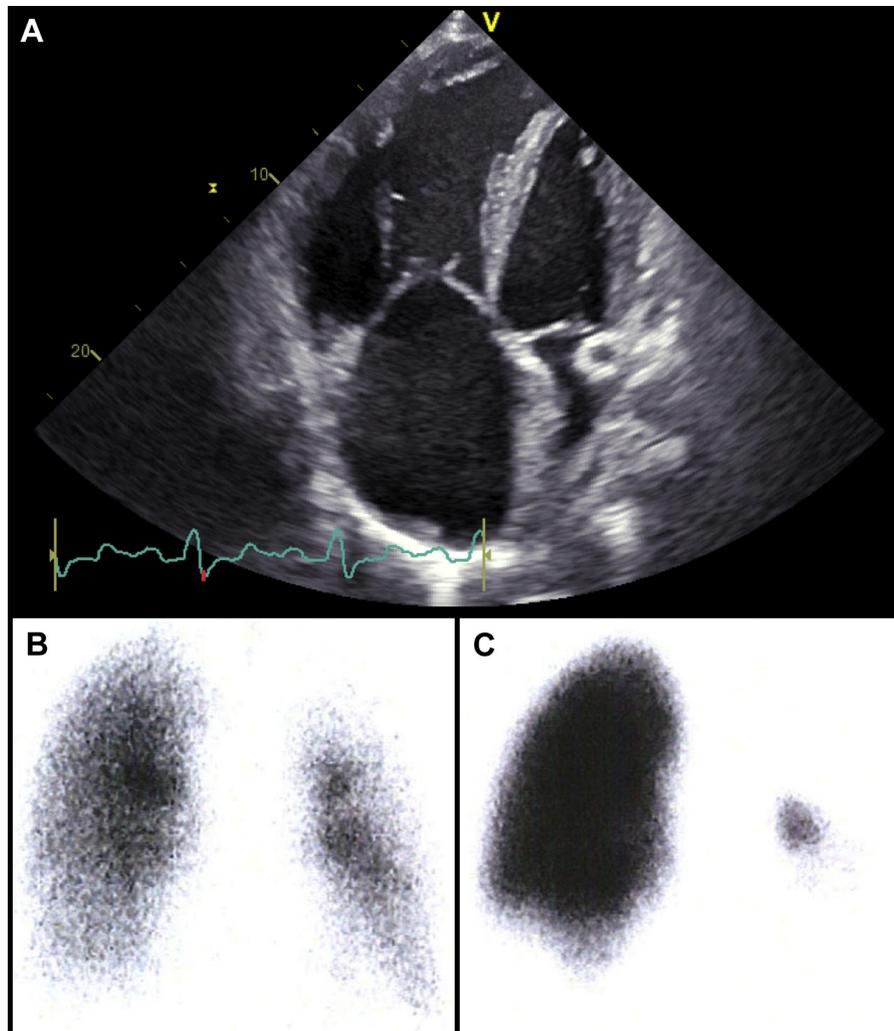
Imaging in a 24-year-old woman with a history of progressive shortness of breath on exertion, deep vein thrombosis, and recent hemoptysis. (A) Transthoracic echocardiographic 4-chamber view with severe right ventricular dilatation. (B) Technetium-99m-labeled aerosol ventilation and (C) perfusion images show nonmatched perfusion defects of right lower lobe and almost the entire left lung.
